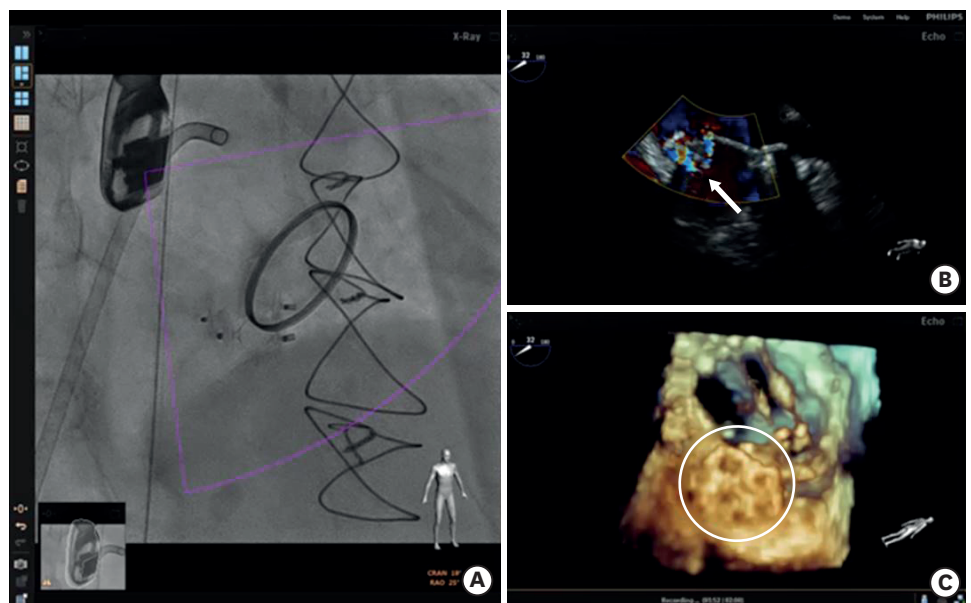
Fusion image from EchoNavigator System (Phillips Healthcare, Best, The Netherlands) after deployment. (A) Final positions of two Amplatzer™ vascular plugs are shown by fluoroscopy. (B) Color Doppler image demonstrated markedly reduced paravalvular leakage (white arrow) compared to Figure 1A. (C) Three-dimensional transesophageal echocardiography demonstrated final position of the vascular plugs (white circle).
